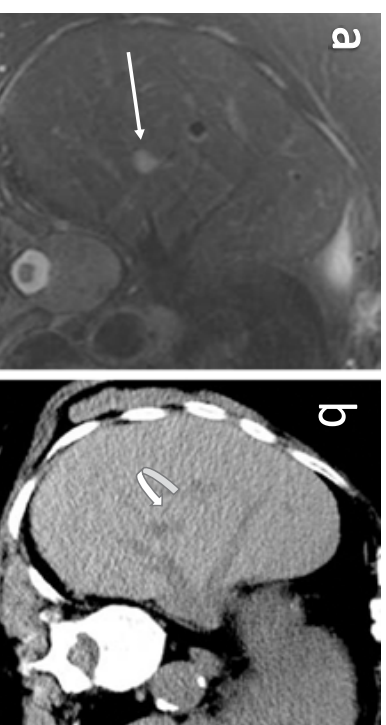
82 year old female patient, stage IV bladder cancer and borderline renal function presented with a growing solitary liver metastasis. The liver is the only site of disease progression. (a) Axial T2-weighted fat-saturated MR image of the liver showing a small hyperintense hepatic lesion in segment VII/VIII (arrow). (b) Non-enhanced CT scan at the same level showing difficulty in differentiating the hepatic lesion (curved arrow) from the adjacent vessels rendering CT-guided ablation less desirable.
